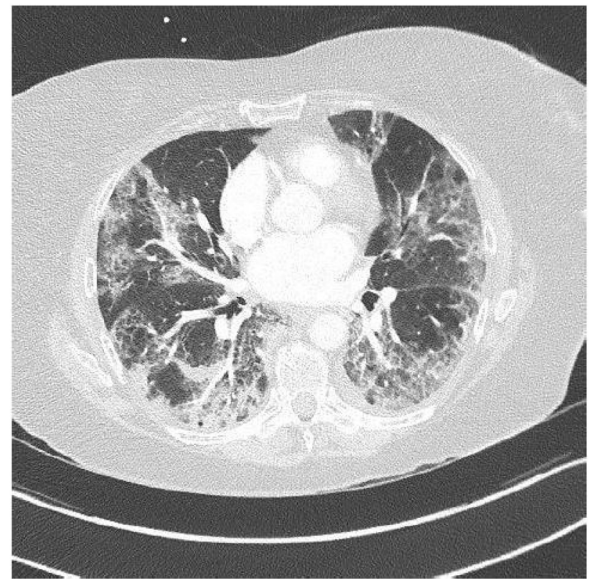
Lung parenchyma lesions in COVID-19: Patient with COVID-19 infection who presented lung parenchyma lesions on chest CT without iodine contrast, stage (extended lesions 50-75 % of lung parenchyma: bilateral peripheral ground-glass opacities: classification of the French Society of Thoracic Imaging.
